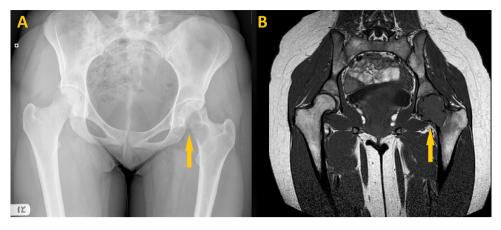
(A) Plain AP radiograph of the pelvis showing a giant cell tumour of bone within the left femoral head and neck (arrow). (B) T1-weighted MRI scan demonstrating the extent of the tumour within the femoral head and neck and corresponding cortical breach (arrow).
